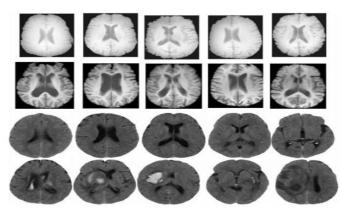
MRI images of healthy and unhealthy brains
